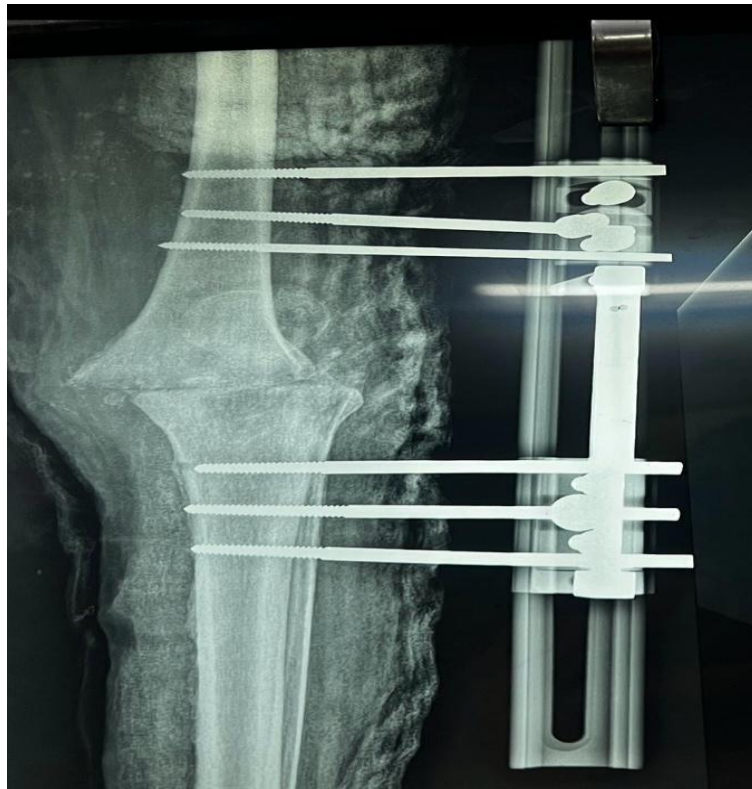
Immediate post - operative antero - posterior plain radiographs showing knee arthrodesis performed with an monorail fixator
